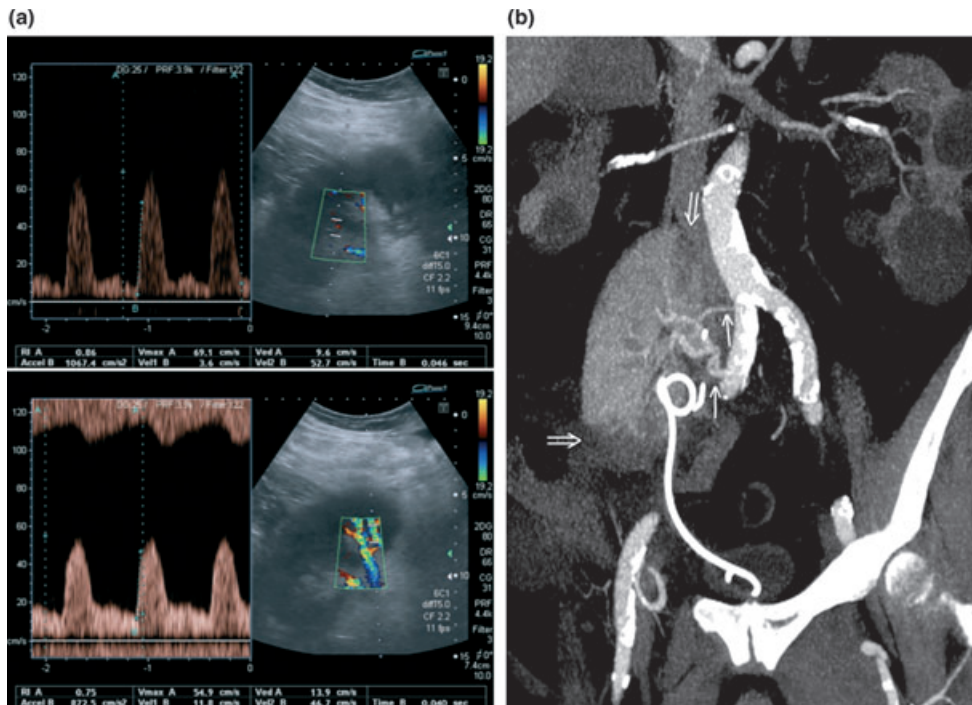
Renal findings. (a) Varying resistance indices (RI) of renal segmental interlobular arteries at different locations of the allograft using colour-coded duplex examination. (b) Contrast enhanced CT in the late arterial phase in coronal oblique maximum intensity projection. Wedge-shaped areas of absent contrast enhancement (⇒) can be appreciated especially at the lower pole, representing areas of renal infarction. Both renal arteries are patent (→).
